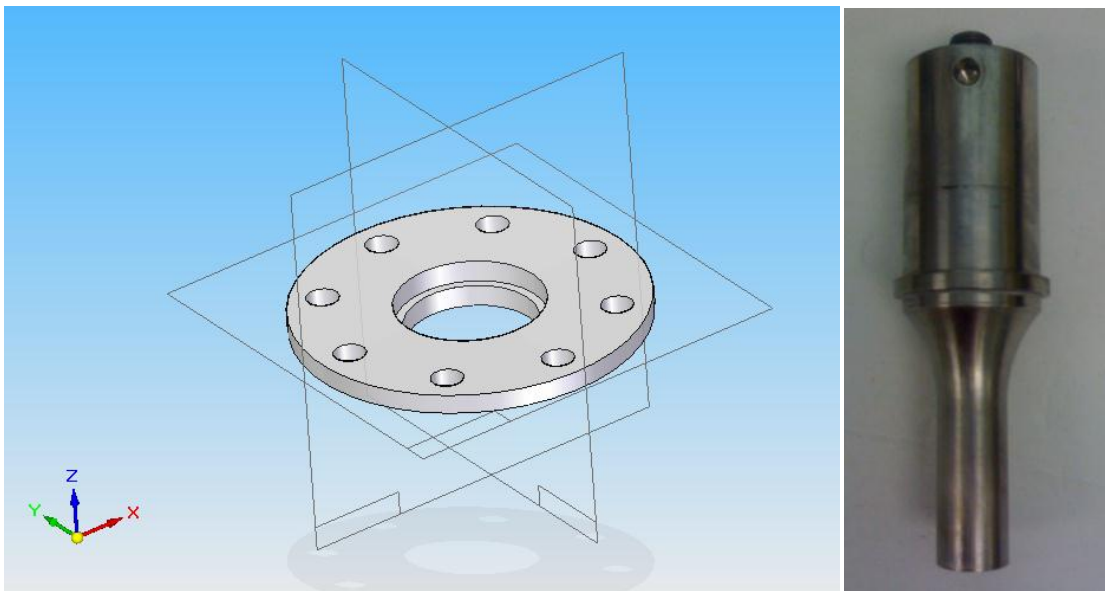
Adapter piece and the ultrasound horn that rests on the lip.
